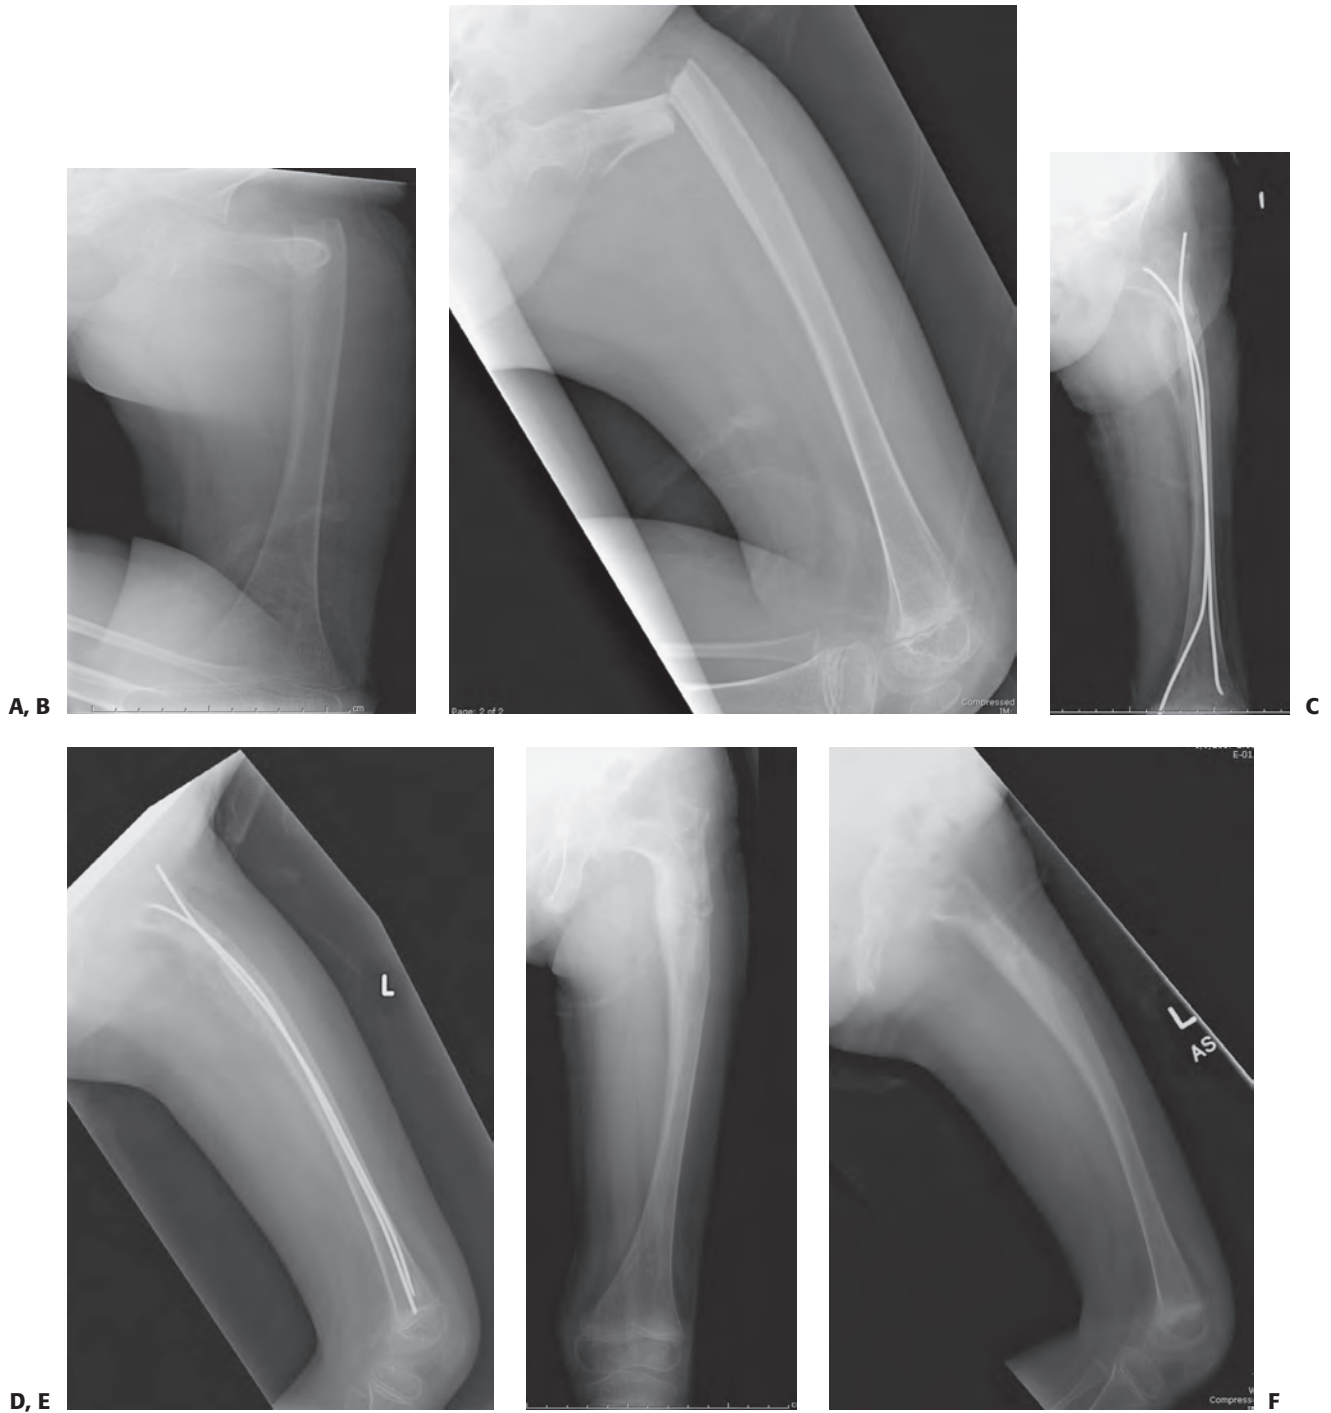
This 8-year-old girl presented with pain and deformity around the right hip after minor trauma. The patient had a known history of osteogenesis perfecta. Initial radiographs (A, B) showed grossly displaced fracture of the proximal femur in the subtrochanteric area. The patient underwent closed reduction and internal fixation with titanium elastic nails, and the fracture healed after 5 weeks, with good alignment in both anteroposterior (C) and lateral (D) views. The nails were slightly prominent and the family elected removal of the hardware (E, F).
